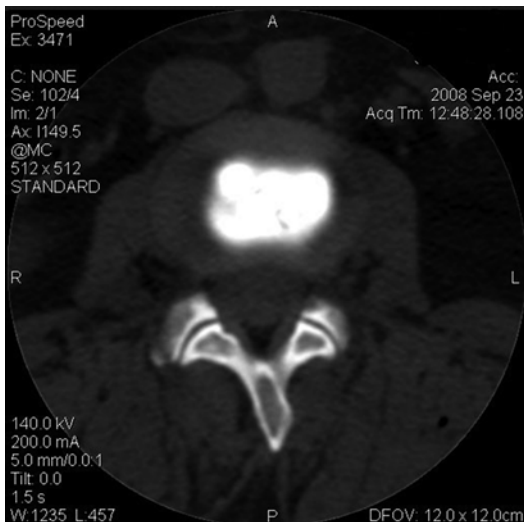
Axial post-diskography CT scan with grade 0 annular tear. Contrast is contained in the nucleus pulposus
